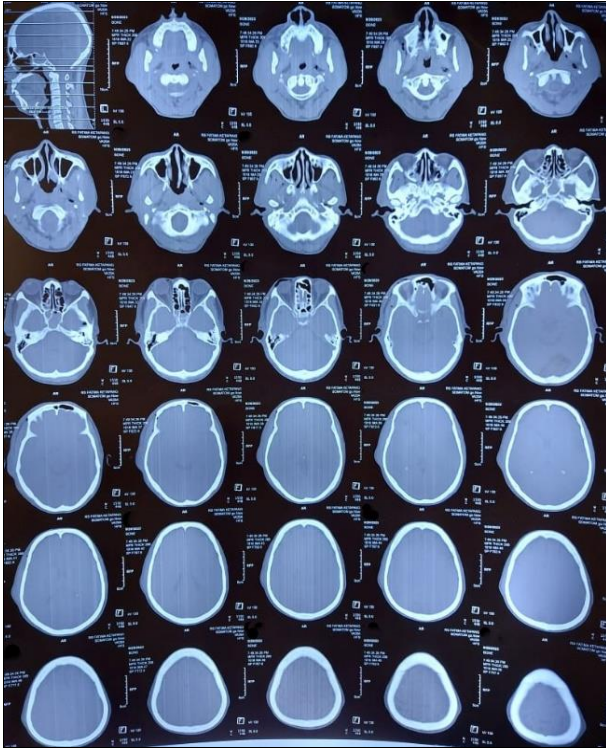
Bone window image of head CT scan after trauma
